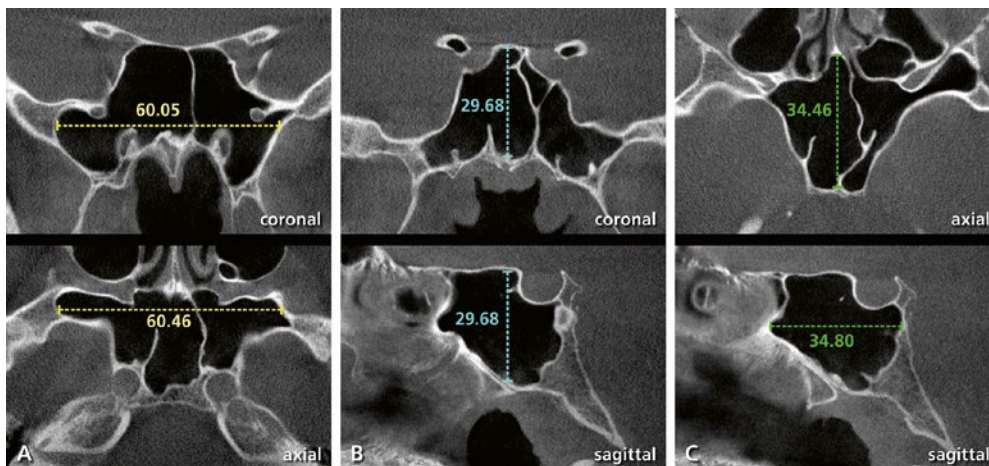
Size measurements of the SPS in CBCT of a 22-year-old male: A = width in the coronal and axial planes; B = height in the coronal and sagittal planes; C = length in the axial and sagittal planes
